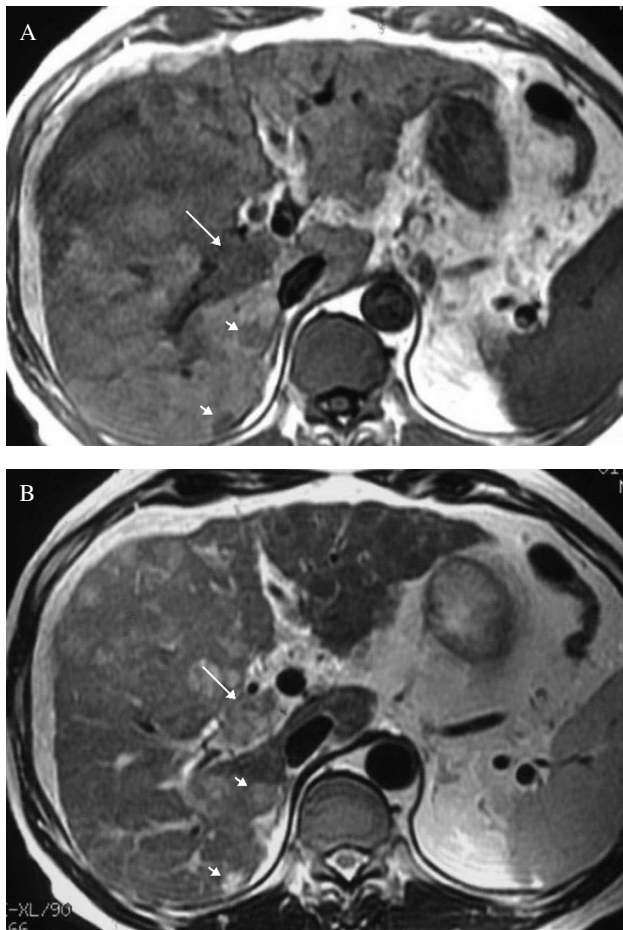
A 43-year-old male with a large HCC and with a serum alpha-fetoprotein level of 63371 ng/ml. On unenhanced T1-weighted axial MR image (A), the tumor involving segments 4, 5, and 8 is seen as areas of heterogeneous hypointensity. Axial T2-weighted MR image (B) demonstrates the tumor as areas of heterogeneous hyperintensity. Also note the expansile thrombus in the right portal vein (arrows). There are also small tumor foci in segment 6 (small arrows).
